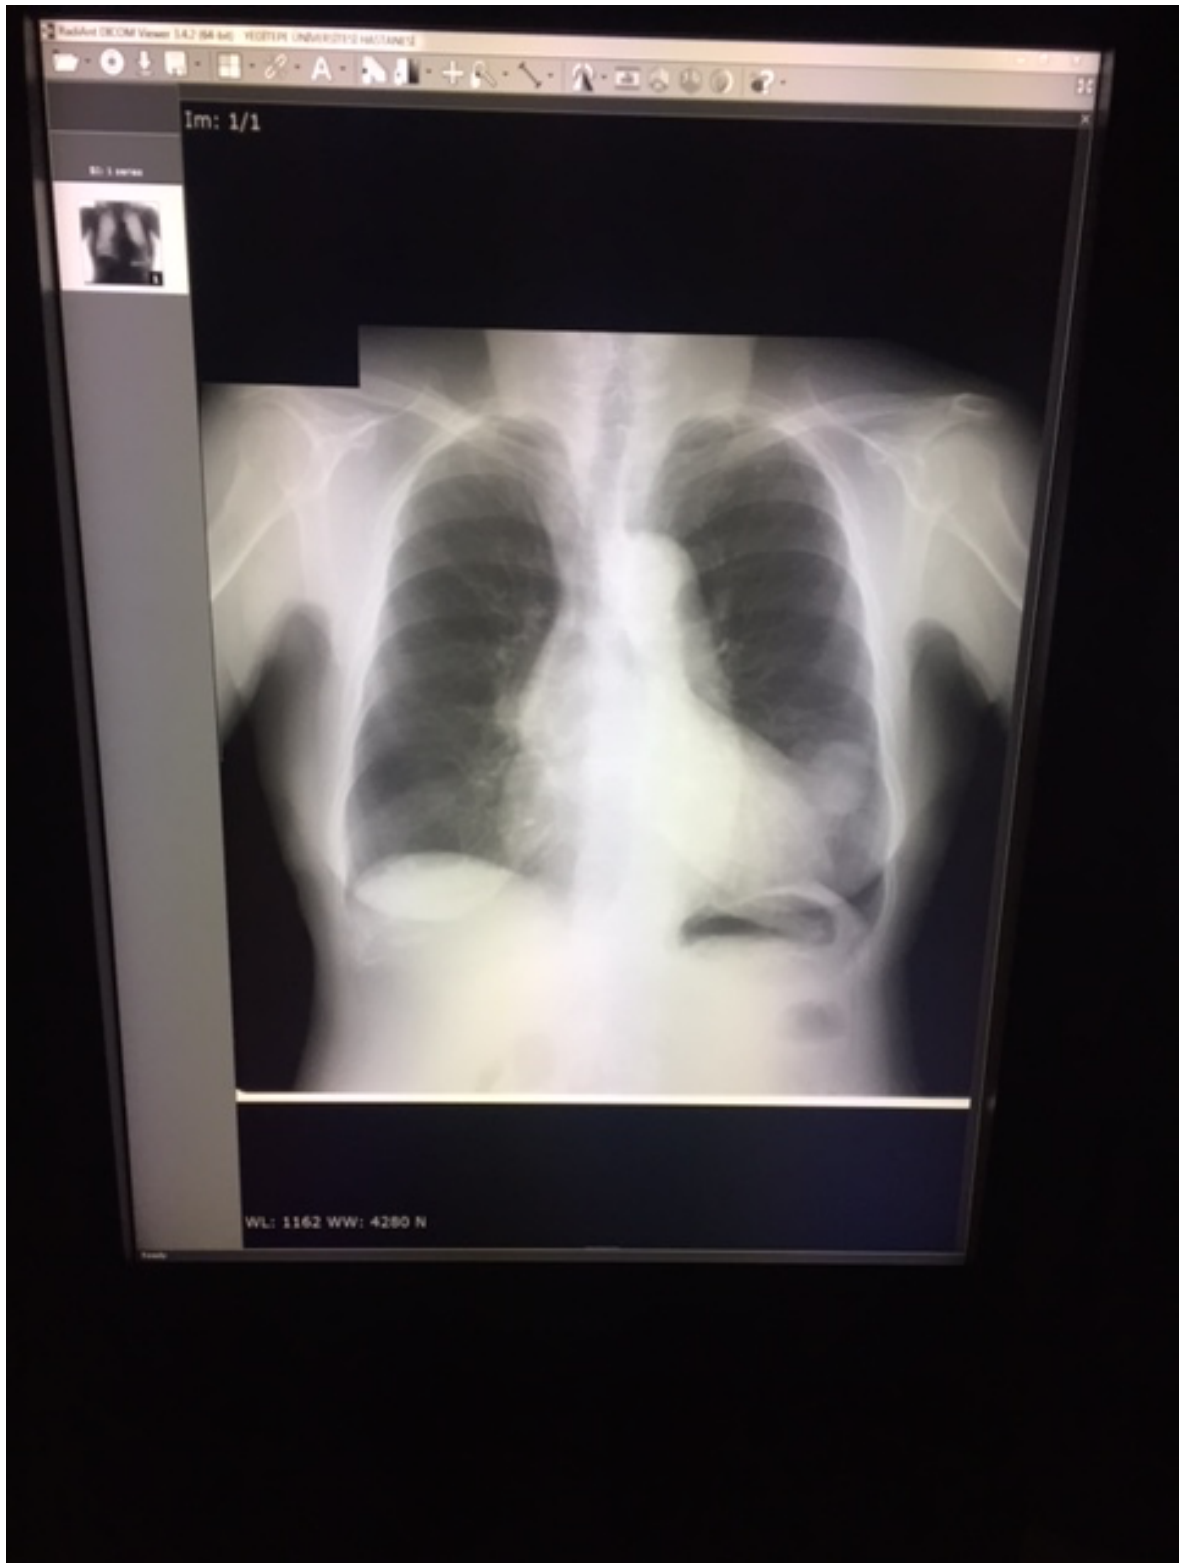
A sample X-ray lung image from the database seen through medical monitor.
